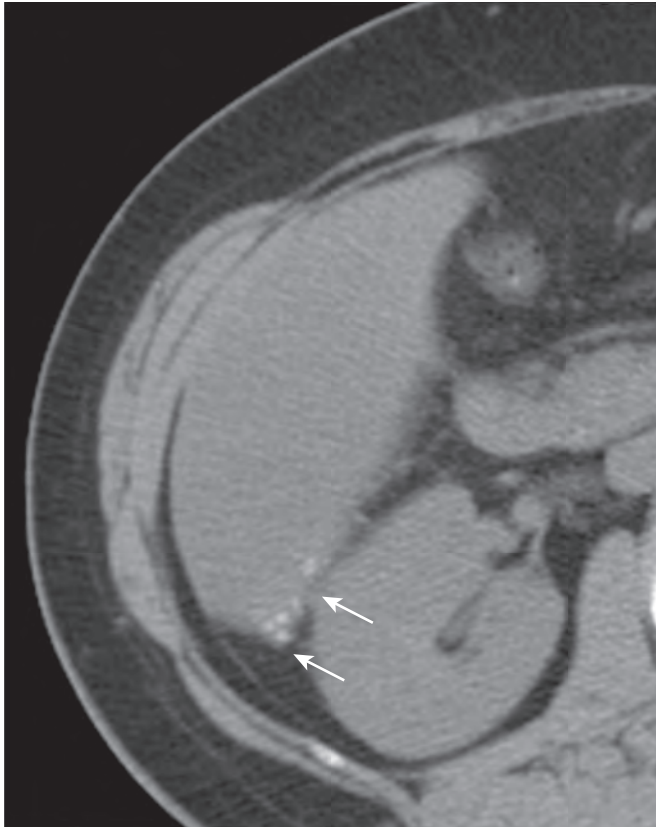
Spilled gallstones. Innumerable tiny dropped gallstones along Morison's pouch (arrows) in an asymptomatic patient several years after LC. Similar appearance of innumerable tiny gallstones was seen on preoperative ultrasound (not shown).
